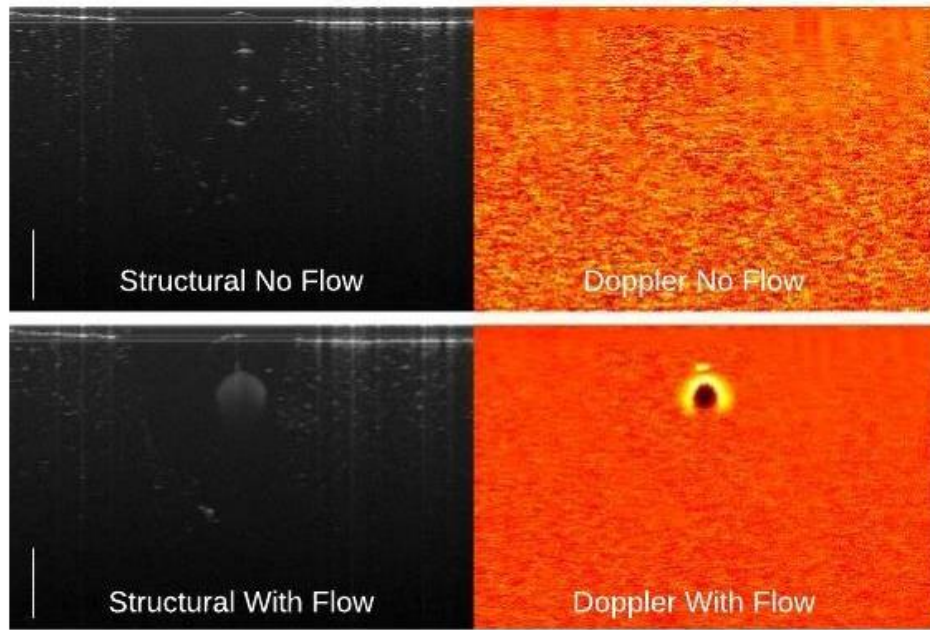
Doppler validation results of the milk flow experiment. The inner and outer diameter of the tubing can be seen upon careful examination. Brightness artifacts obscure the upper portion of the tube. Scale bars in the structural image represent 0.5 mm. The Doppler signal is only present when there is flow and thus the system is functioning as expected.
